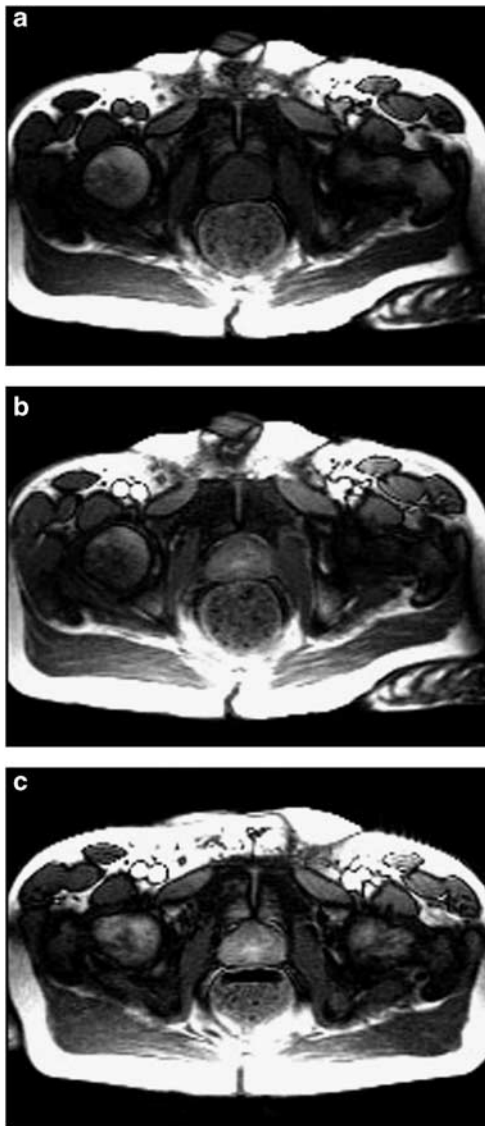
(a) MRI image of the prostate as baseline before the injection of gadolinium. Note the almost equivalent intensity of the obturator, muscle and prostate. (b) MRI image of the prostate at maximum enhancement after gadolinium injection. No sildenafil was given during this study. (c) MRI image of separate MRI study on different day after a dose of sildenafil 50 mg, and injection of gadolinium. Note greater enhancement of the gland than in (b), and note the graphic analysis in Figure 1a and b.
